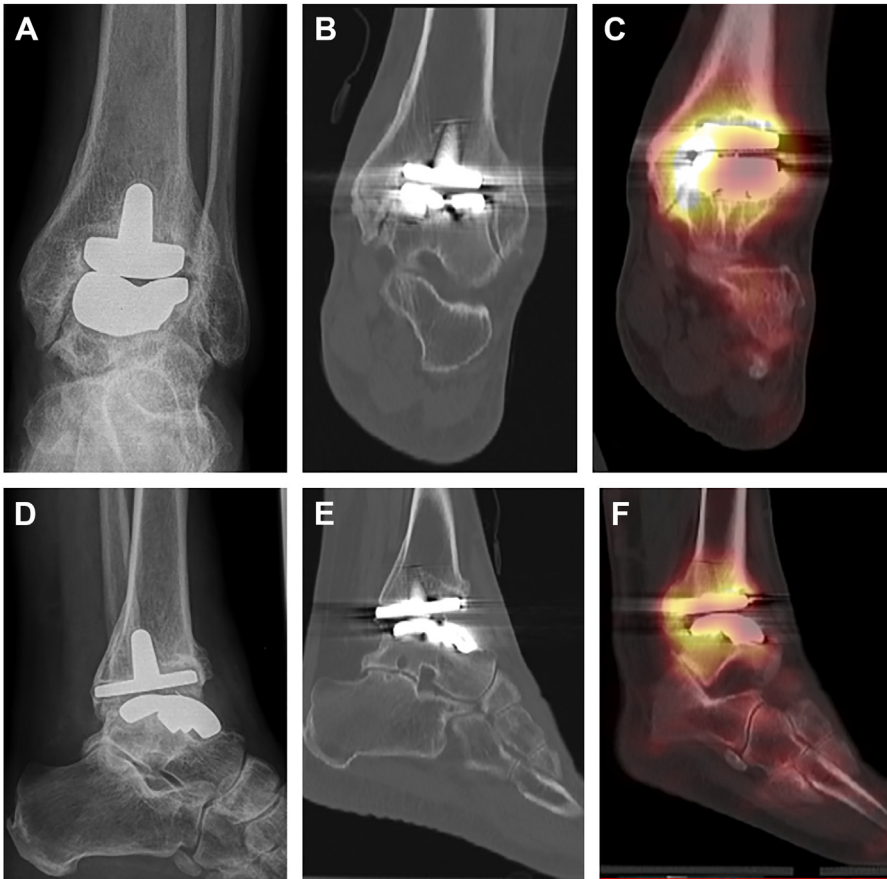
Aseptic prosthetic loosening. A 56-year-old man presented with pain at rest and under stress 8 years after implantation of total ankle prosthesis. Clinical examination was inconclusive to differentiate prosthetic loosening and subtalar osteoarthritis. (A, D): Radiographs showed talar cyst formation assuming prosthetic loosening and incipient osteoarthritis in the posterior part of the subtalar joint. (B, E): Also CT-scans show both periprosthetic loosening zones and subtalar degenerative changes. For preoperative decision making regarding the need of arthrodesis both in the ankle and subtalar joint, SPECT/CT was performed. (C, F): Hybrid imaging showed prosthetic loosening both of the tibial and talar component with relevant tracer enhancement. There was no tracer enhancement of subtalar joint. Removal of total ankle prosthesis and arthrodesis with autologous interposition bone graft was planned.
